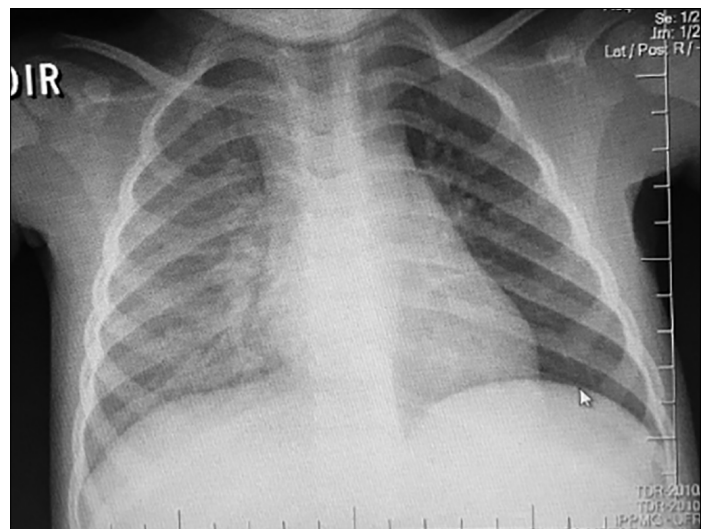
Chest X-rays: inspiration phase.
